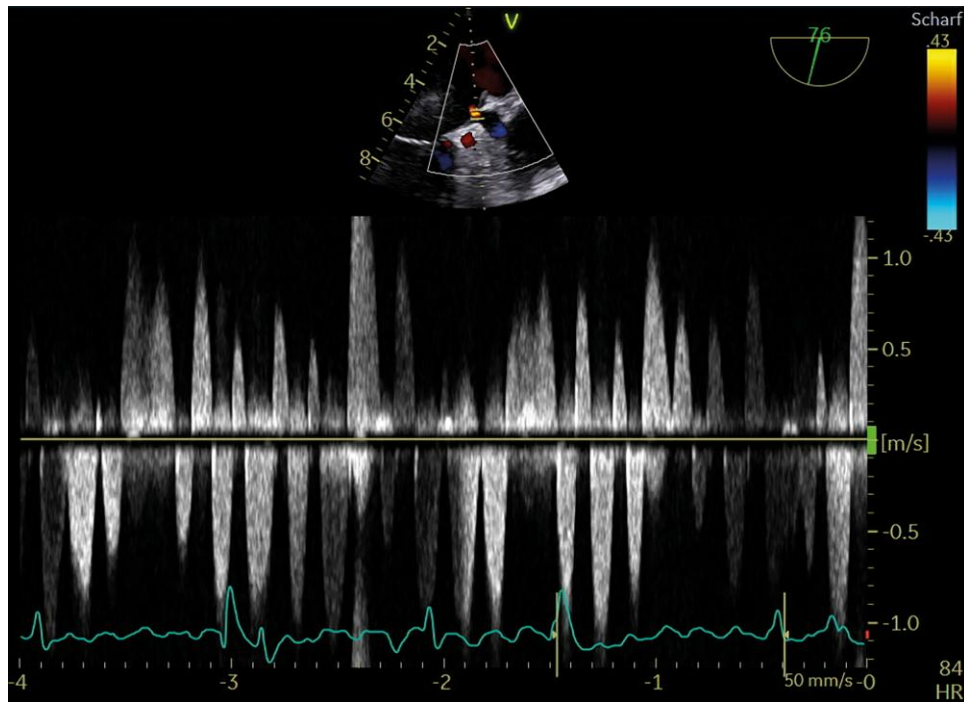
Transoesophageal echocardiographic image of pulsed wave Doppler displaying the to and fro flow at the LAA ostial narrowing with a frequency of 280–300/min according to the flutter frequency (midoesophageal, 79°).
